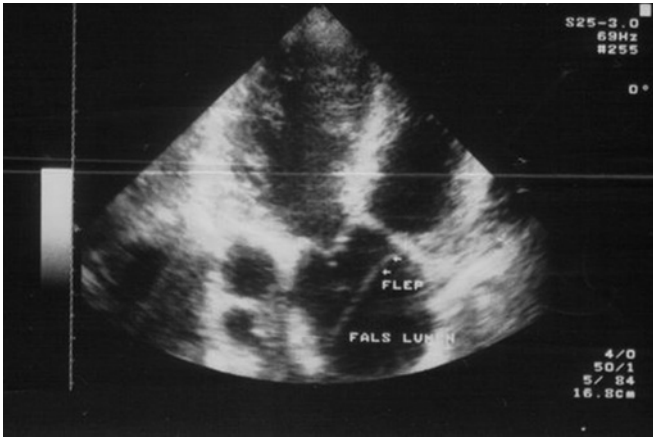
Preoperative echocardiographic appearance of the dissection flap (patient no. 21).
